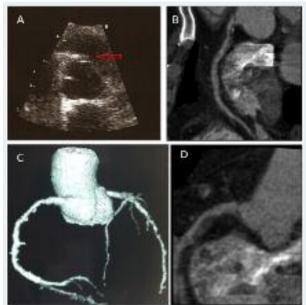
A- a limited aortic dissection in Transthoracic echocardiography.
